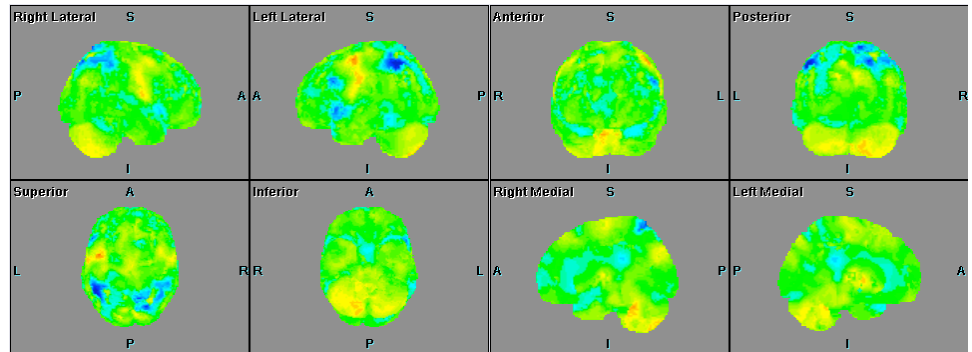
Stereotactic surface projection of uptake image for a FDG-PET case; cf. Figure 3. Note area of reduced uptake in the region of the parietal lobe.
